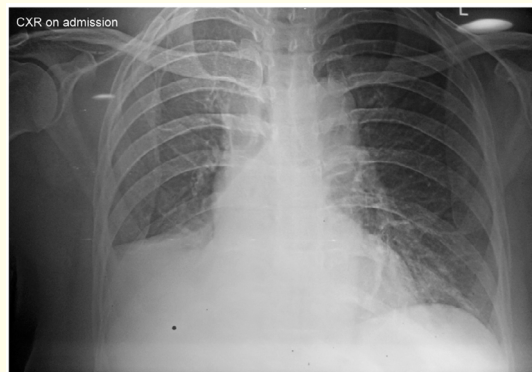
Chest X-ray on presentation showing complete collapse of right lower lobe.
